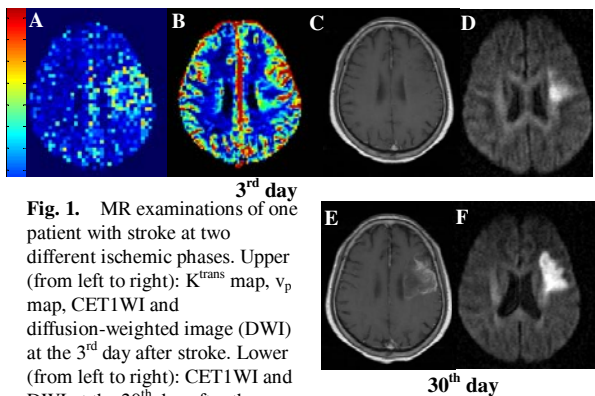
MR examinations of one patient with stroke at two different ischemic phases. Upper (from left to right): K^{trans} map, v_p map, CET1WI and diffusion-weighted image (DWI) at the 3rd day after stroke. Lower (from left to right): CET1WI and DWI at the 30th day after the onset of symptoms.
